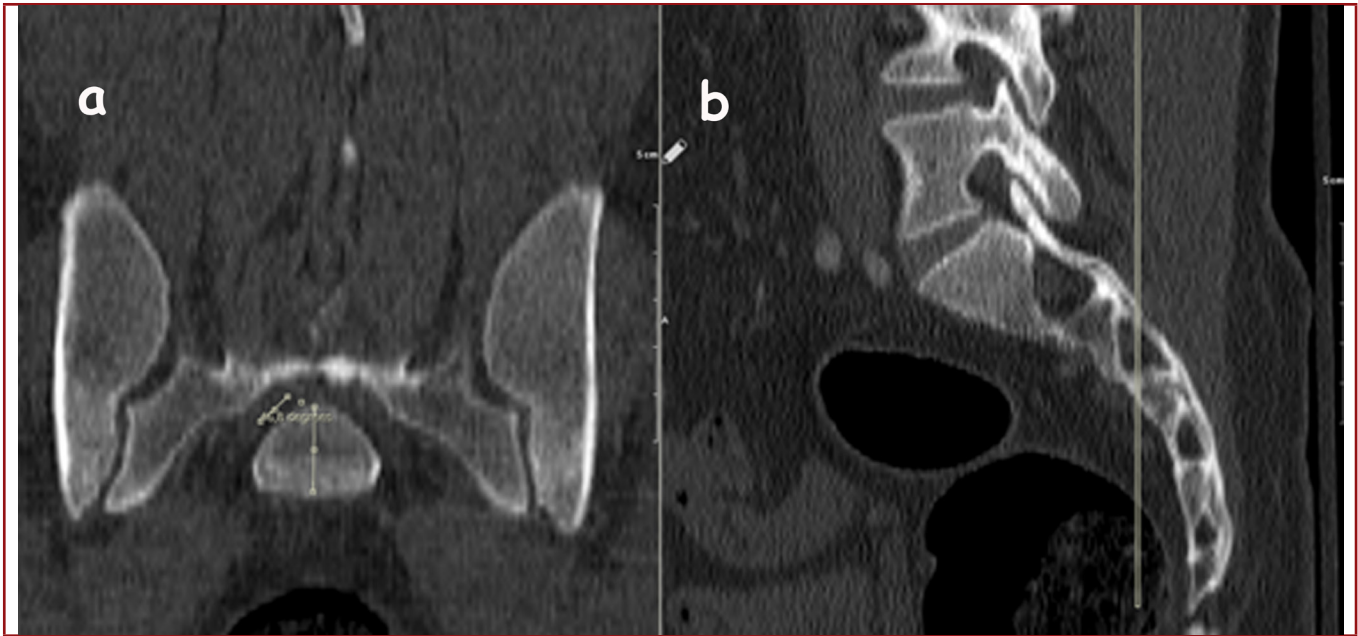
CT of the pelvis a) The coronal view of the S2NRT. The tunnel course angle from the midline measured between vertebral corpus vertical line and the S2NRT line. b) The sagittal CT section, showing the coronal view orientation which was used to measure the S2NRT course angle.
